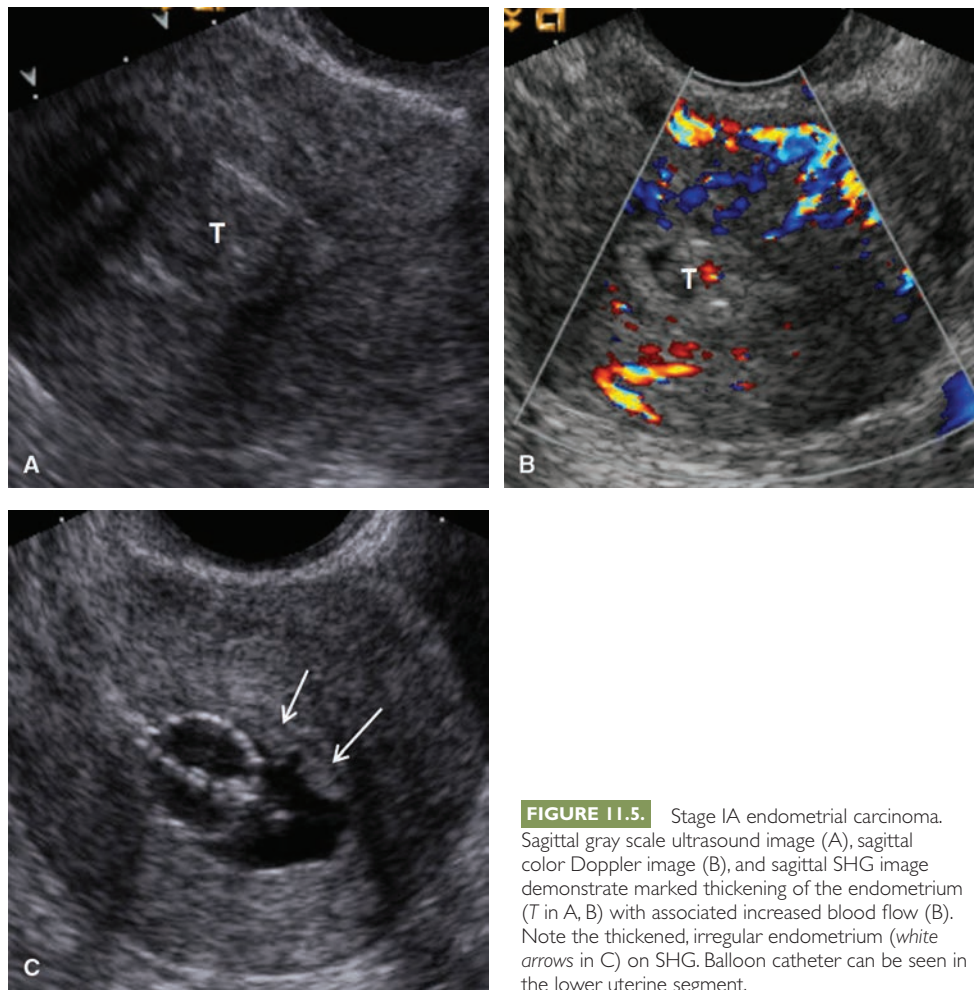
Stage IA endometrial carcinoma. Sagittal gray scale ultrasound image (A), sagittal color Doppler image (B), and sagittal SHG image demonstrate marked thickening of the endometrium (T in A, B) with associated increased blood flow (B). Note the thickened, irregular endometrium (white arrows in C) on SHG. Balloon catheter can be seen in the lower uterine segment.
